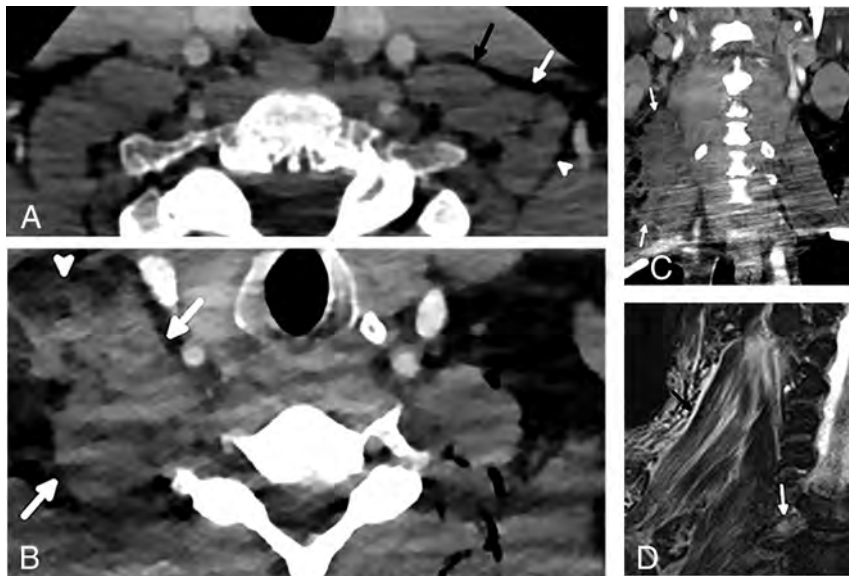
Normal and abnormal scalene muscles in different patients. An axial CT image in a 48-year-old man (A) without BPI shows normal anterior (black arrow), middle (white arrow), and posterior (arrowhead) scalene muscles without enlargement or edema. An axial CT image in a 52-year-old man (B) with BPI shows enlargement of the right scalene muscles (arrows) with extensive surrounding edema (arrowhead). A coronal CT image in the same patient (C) shows the extent of the asymmetric edema (arrows). A coronal T2 STIR MR imaging performed a day later in the 52-year-old patient (D) again shows scalene enlargement and edema (black arrow). Thickening and signal hyperintensity within the right C7 root (white arrow) are consistent with a stretch injury; similar findings were present at other levels.
